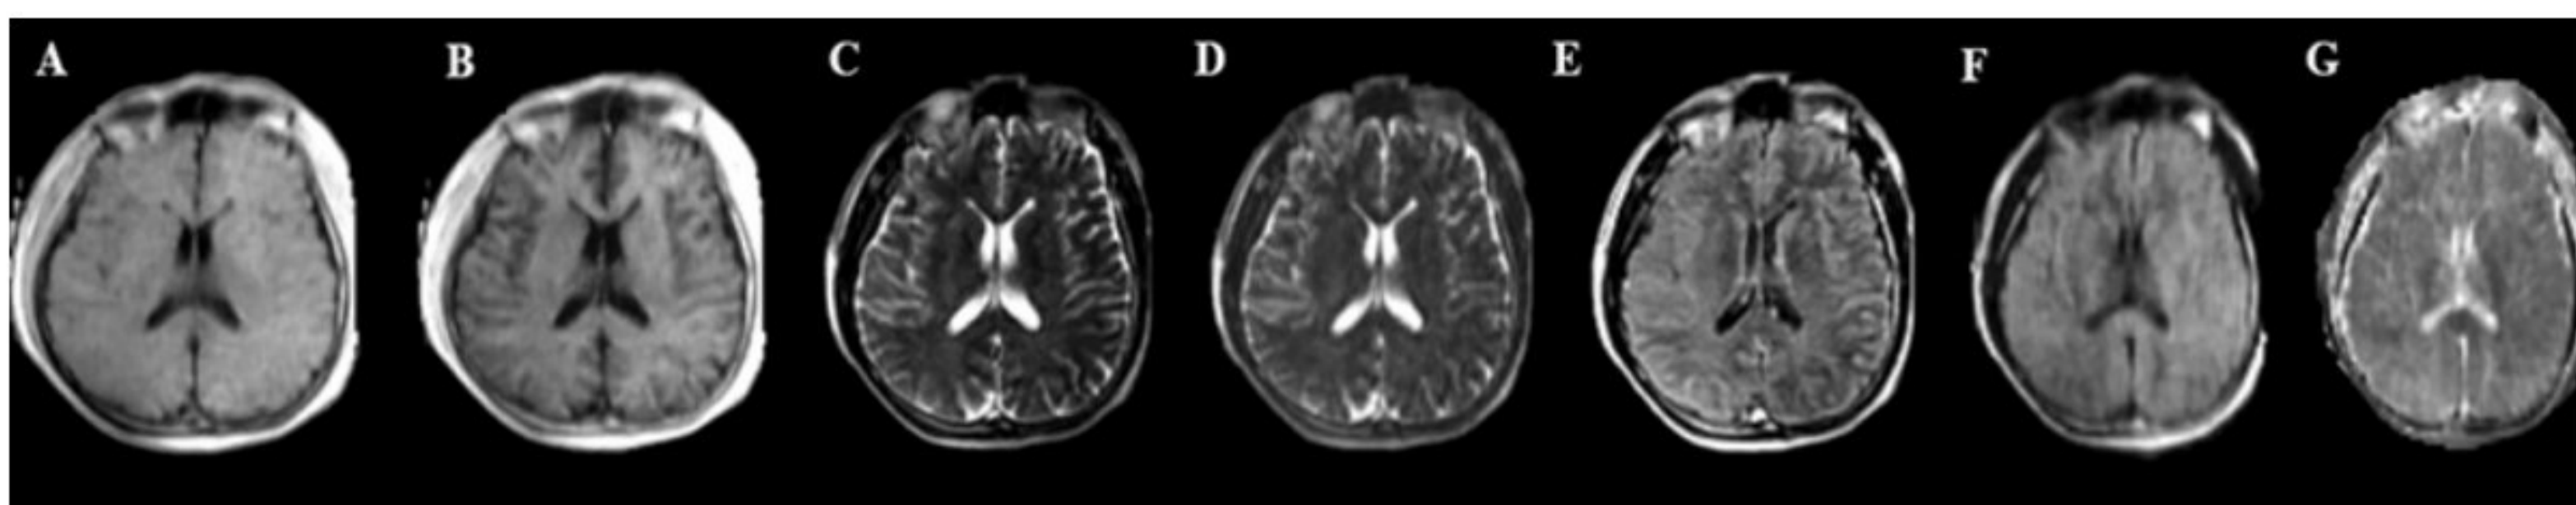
Sequences of portable MR imaging system. (A) T1 (Standard), (B) T1 (Gray/White), (C) T2, (D) Fast T2, (E) Fluid-Attenuated Inversion Recovery (FLAIR), (F) Diffusion-Weighted Imaging (DWI), (G) Apparent Diffusion Coefficient (ADC) Map
